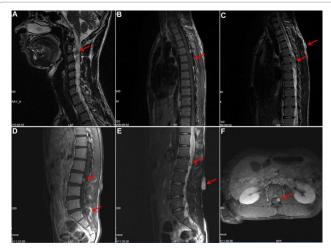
MRI scan of the spinal cord showing several intraspinal masses. (A) Sagittal T2-weighted MRI showing a dumbbell-shaped abnormally low signal in the right intervertebral foramen at the C2-3 level, approximately 13 mm × 15 mm × 15 mm in size. (B) Sagittal T1-weighted MRI and (C) Sagittal T2-weighted MRI showing a dumbbell-shaped abnormal intraspinal mass in the right intervertebral foramen at the T5-6 level, approximately 37 mm × 12 mm × 40 mm in size. The epidural mass was then excised and confirmed as a schwannoma by a pathologist. (D) Sagittal T1-weighted MRI, (E) Sagittal T2-weighted MRI, and (F) Transverse T1-weighted MRI showing multiple nodules in the lumbar vertebral canal. The largest was approximately 11 mm × 9 mm × 8 mm in size at the L2 level. Oval-shaped masses on both sides of the spine at the L5-S1 level are also visible, approximately 31 mm × 18 mm in size. A 31 mm × 10 mm oval subcutaneous mass is also shown on the back at the L3 level.
